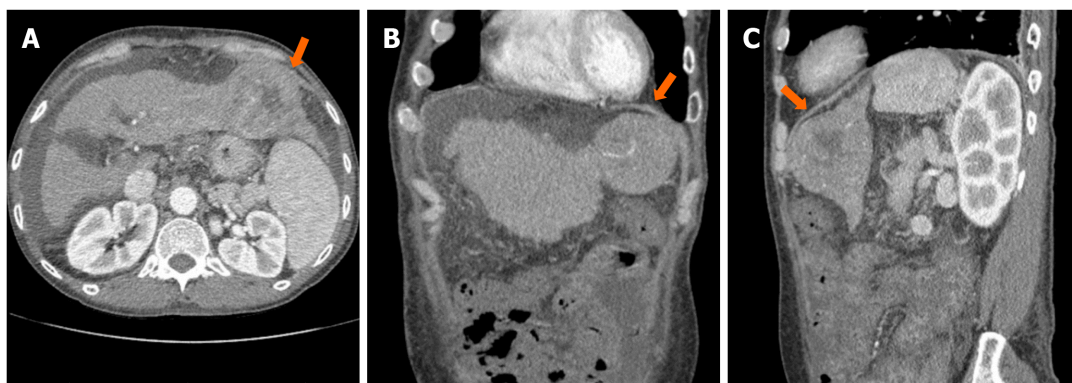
Arterial phase of abdominal computed tomography showed a centrally necrotic mass in the left hepatic lobe, measuring 6.7 cm × 6.5 cm (orange arrow). A: Axial view; B: Coronal view; C: Sagittal view.
